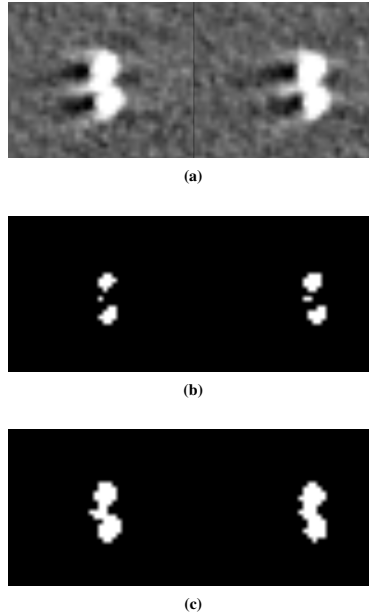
Two subsequent slices of the CTA data. (a) shows a close-up of the intensity data. (b) and (c) depict the application of two different thresholds to the same image slices.
